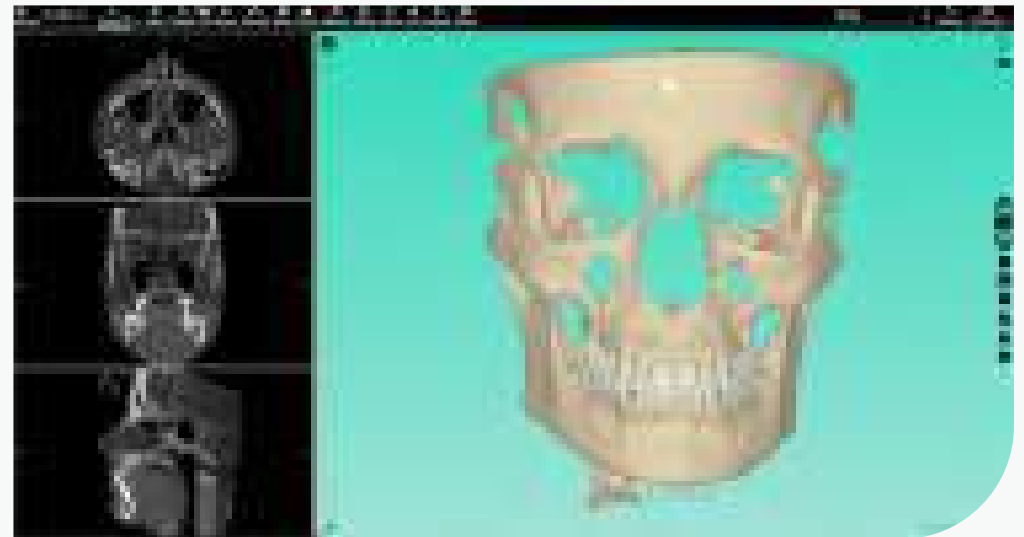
Smilers® Expert: Integration of CBCT.
